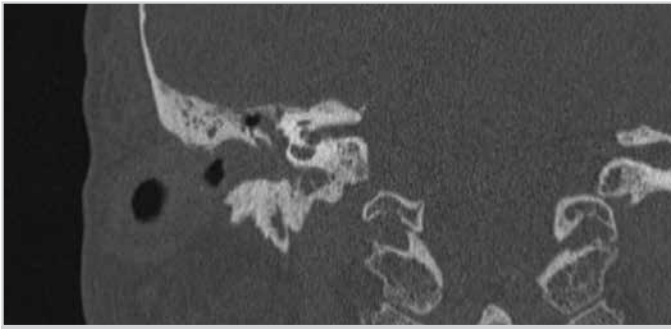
Preoperative coronal section temporal CT scan showing a soft tissue density in the middle ear cavity extending to the external ear canal
